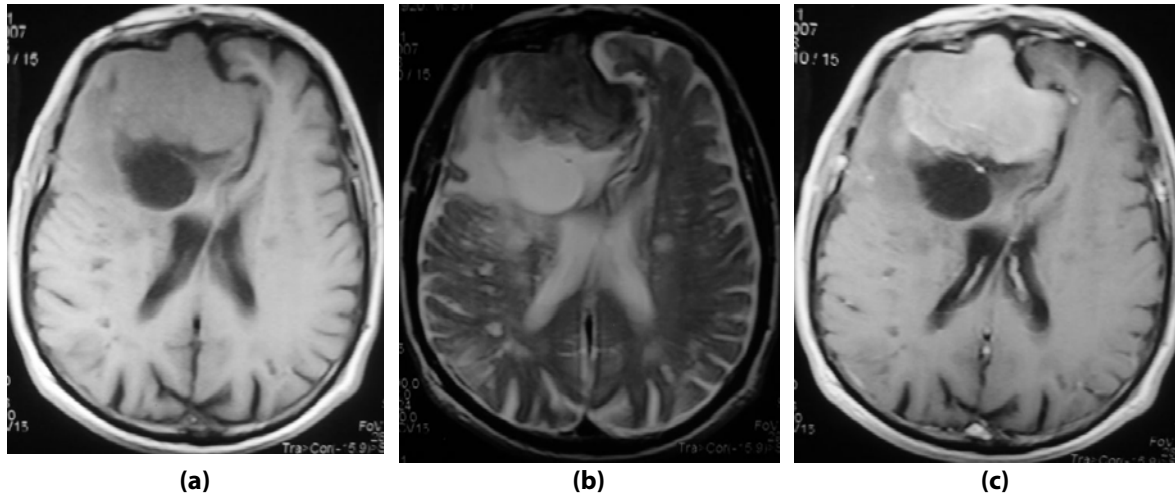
Preoperative T1-weighted (a), T2-weighted (b), and contrast-enhanced T1-weighted (c) MR images show right frontal mass.
